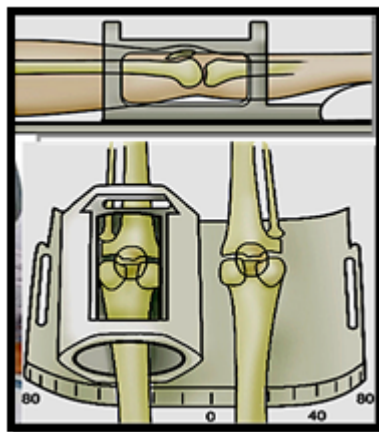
Positioning for MRI Knee joint
